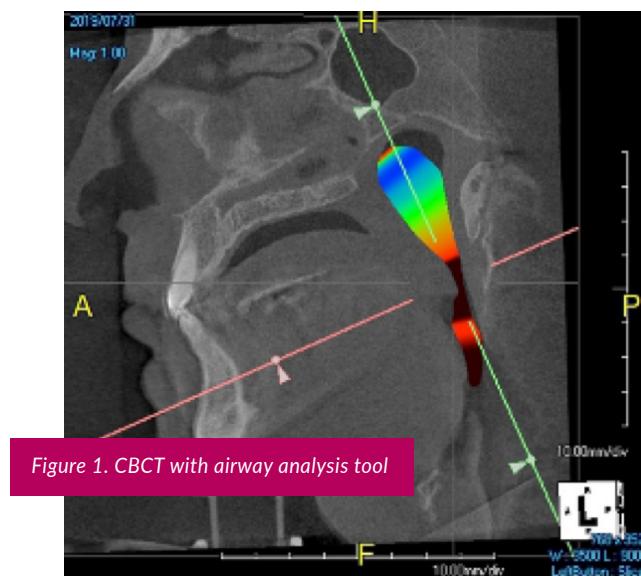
CBCT with airway analysis tool
